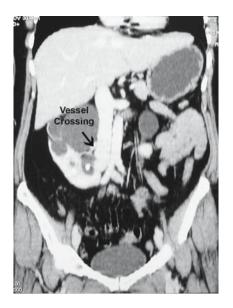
A spiral CT scan shows a lower polar vessel crossing the ureter on the right side
